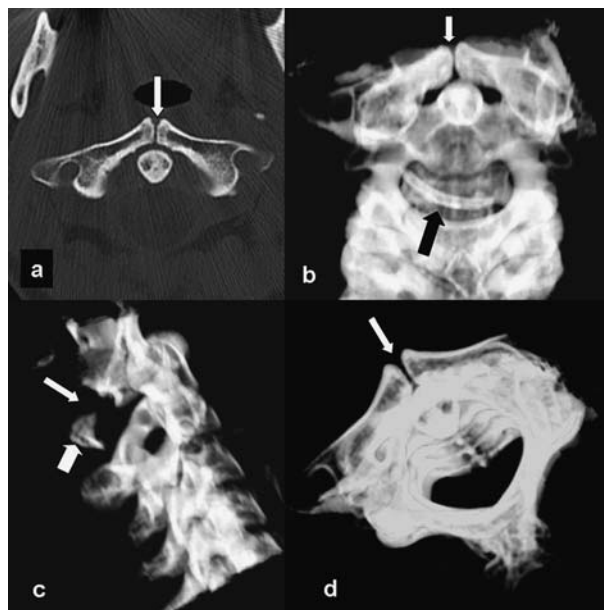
Multidetector computed tomography of congenital atlas dysplasia. a) The axial high resolution image shows the anterior rachischisis (arrow). b) 3D reconstruction shows the anterior rachischisis (arrow) and the isolated tubercle (black arrow). c) The lateral 3D reconstruction shows to better advantage the complete atlas cleft (arrow) and the tubercle (thick short arrow). d) Anterior rachischisis is obvious from another 3D reconstruction (arrow).
